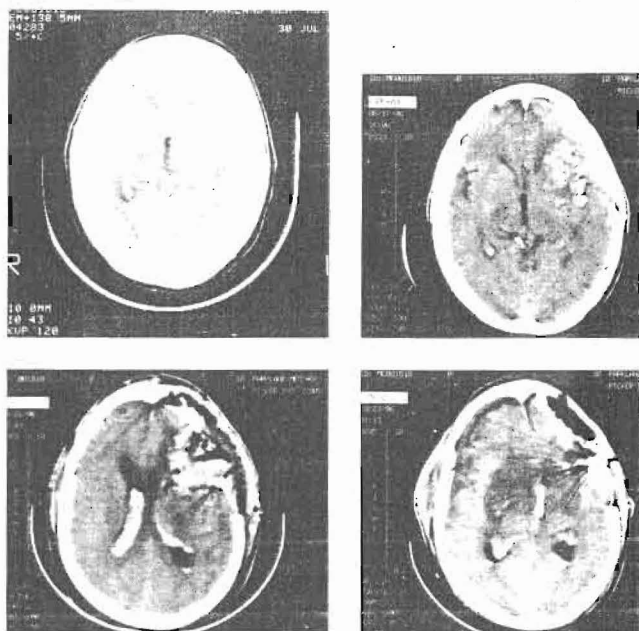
CT scans obtained during the patient's hospital course: *Top left*, enhanced CT scan 1 week after the ictus shows SAH with an enhancing parasylvian mass. *Top right*, after flow-directed embolization, the CT scan reveals an accumulation of polyvinyl alcohol foam particles within the substance of the malformation. *Bottom left*, immediately after clinical deterioration 48 hours postoperatively, a CT scan reveals clot within the resection site associated with moderate ventricular hemorrhage and significant frontal mass effect. *Bottom right*, final CT scan obtained when the patient developed diabetes insipidus and brain stem dysfunction showing remarkable bilateral diencephalic low density and shift from right to left.
